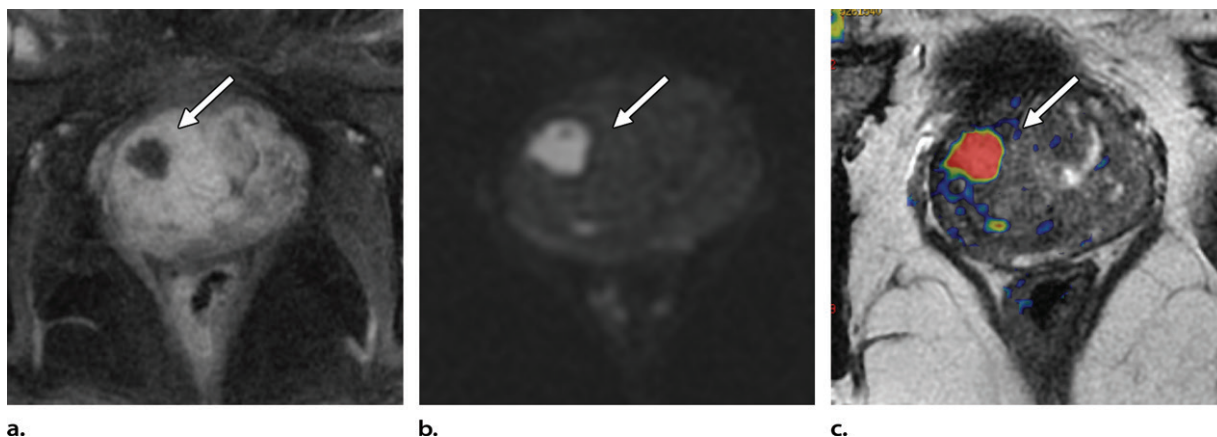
Axial dynamic contrast-enhanced (a), diffusion-weighted (b), and fusion T2-weighted–diffusion-weighted (c) MR images acquired 1 year after PAE in a 69-year-old man show a small well-defined avascular area (arrow) in the right prostate central zone and diffusion restriction in the same area, which is consistent with a prostate focal abscess. (Figure 22 reprinted, with permission, from reference 64.)
